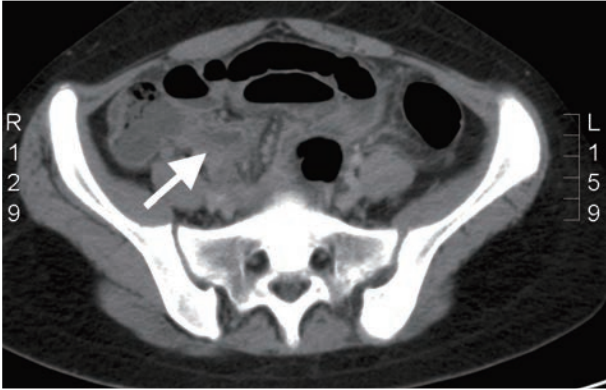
CT scan revealed swollen appendix mimicking a mass lesion.
